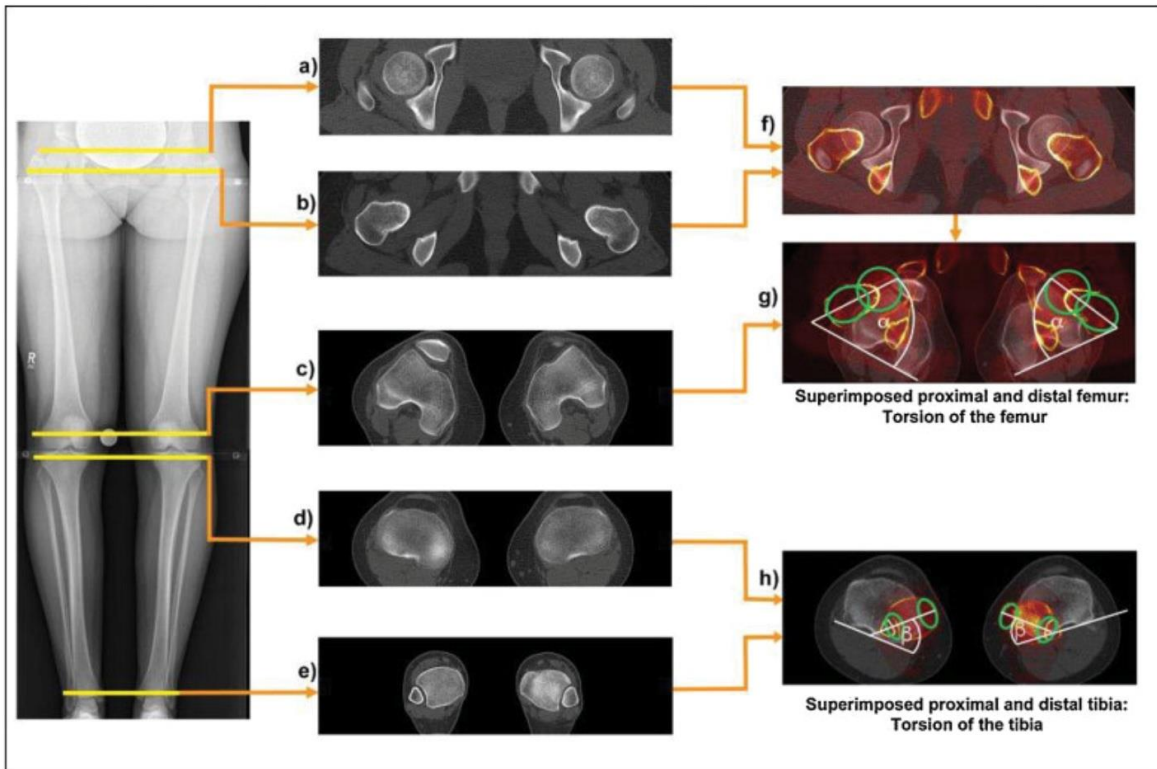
Rotational profile CT scan with explanation of the superimposed images used to measure long bone torsion (Included with author permission from [151])
